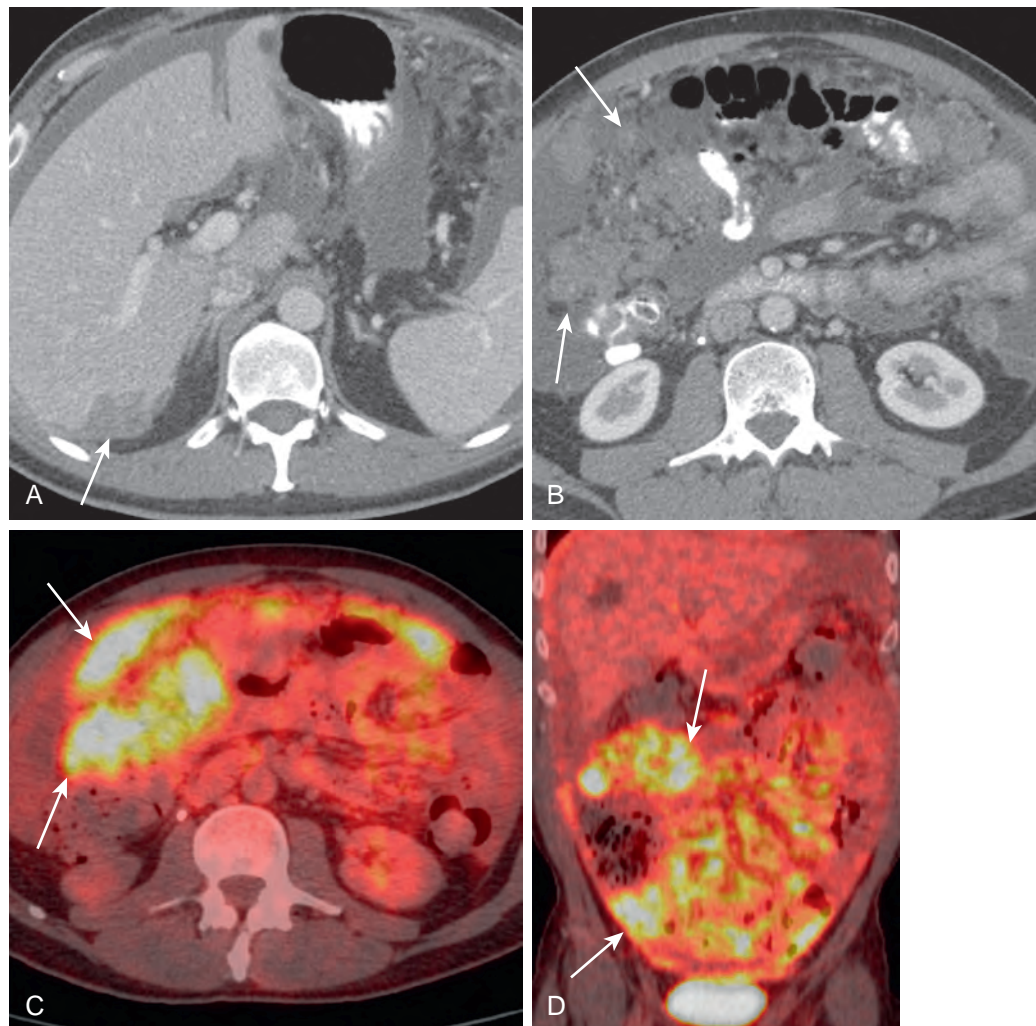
Mesothelioma. A. Patient with peritoneal mesothelioma demonstrating an implant (arrow) along the posterior liver. B. Infiltration with masses (arrows) along the mesentery. C. Axial PET/CT demonstrating FDG-avid masses (arrows) along the small bowel mesentery. D. Coronal PET/CT demonstrating diffuse peritoneal (arrows) involvement.
